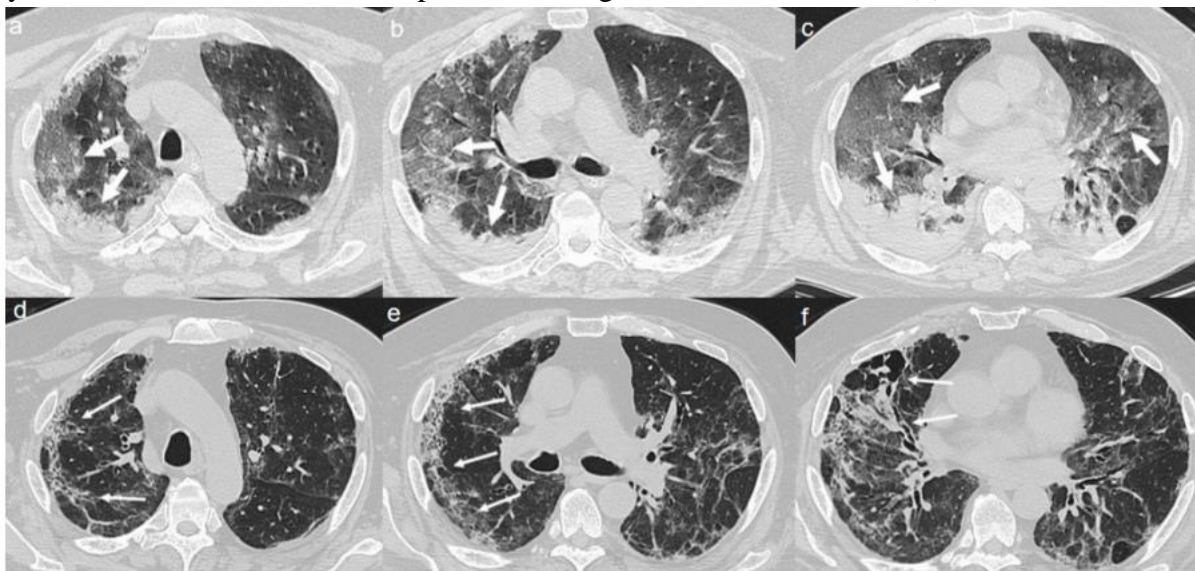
(a–c) CT shows bilateral extensive areas of GGO and consolidations, with prevalent peripheral distribution, in upper and lower lobes (arrows). (d–f) Follow up CT 4 months after admission shows persistence of diffuse thickening of the interlobular septa, with fibrotic appearance (thin arrows in d,e); air bubble sign with bronchiectasis (thin arrows in f) is recognizable.
